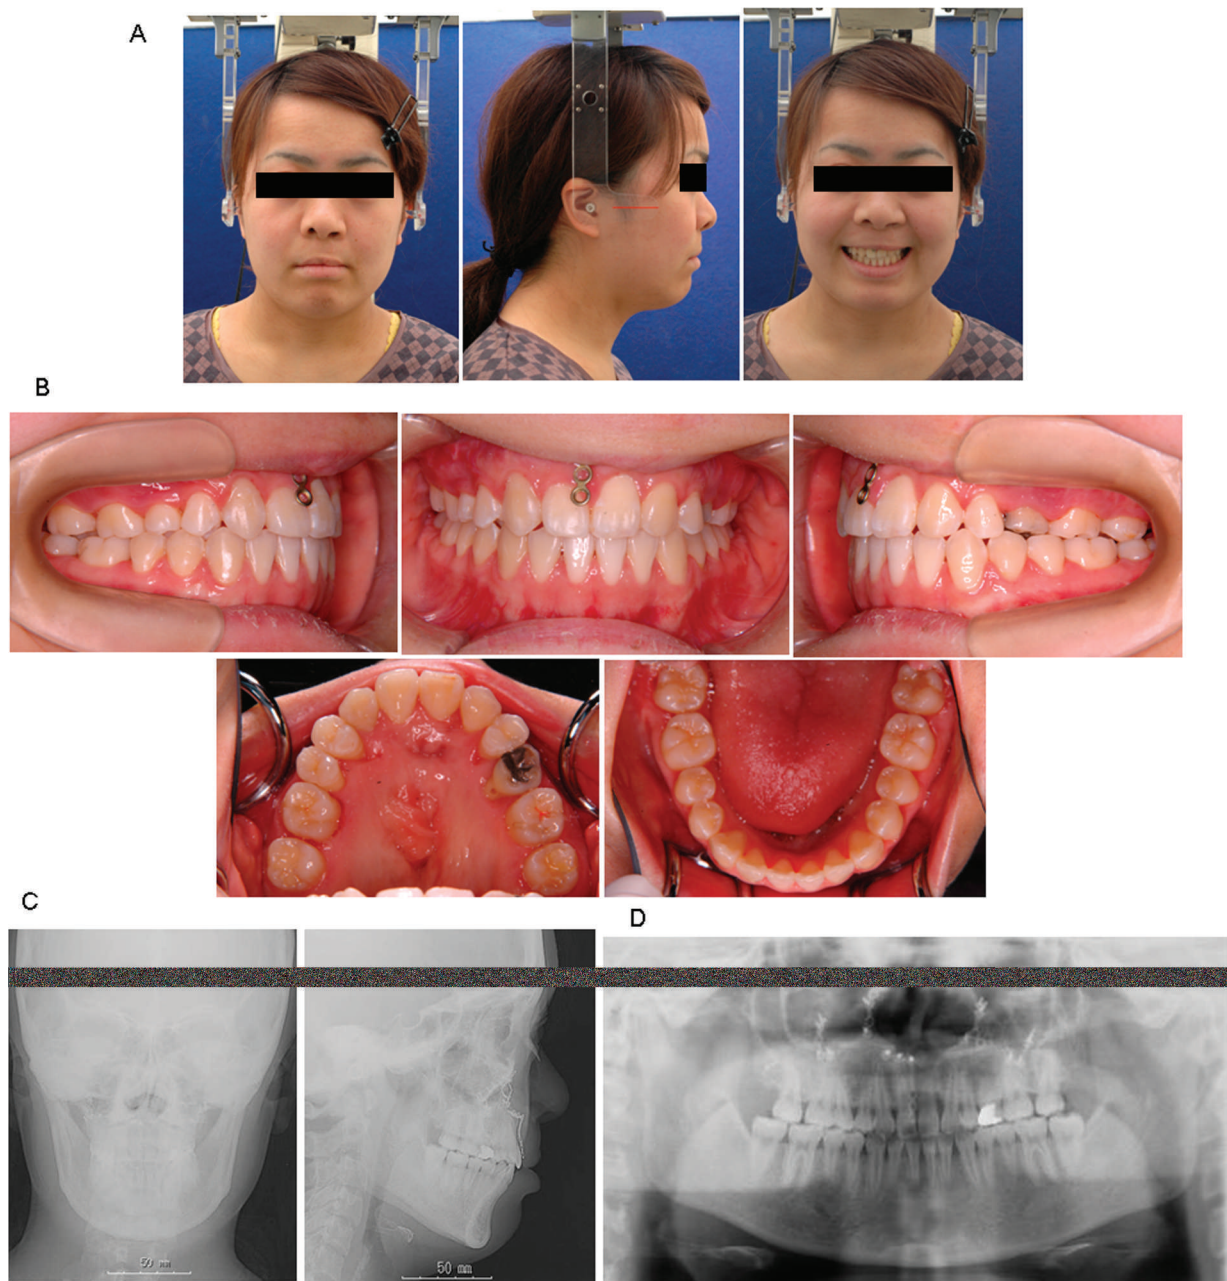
Posttreatment records (age, 20 years 1 month). (A) Facial photographs. (B) Intraoral photographs. (C) Frontal and lateral cephalograms. (D) Panoramic radiographs.
